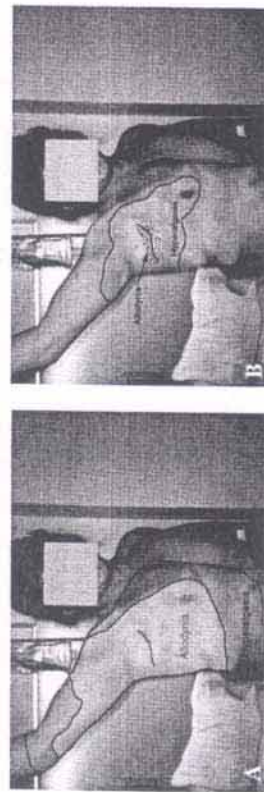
A, Case report. Patient prior to SA infusion presents with a large area of allodynia surrounded by a larger area of pinprick hyperalgesia after a transthoracic sympathectomy. B, After 250 mg of IV SA (in the absence of sedation), allodynia has been replaced by a small area of hypoesthesia surrounding the sympathectomy scar, while pinprick hyperalgesia has "shrunk" to the territory of the intercostobrachial nerve.
